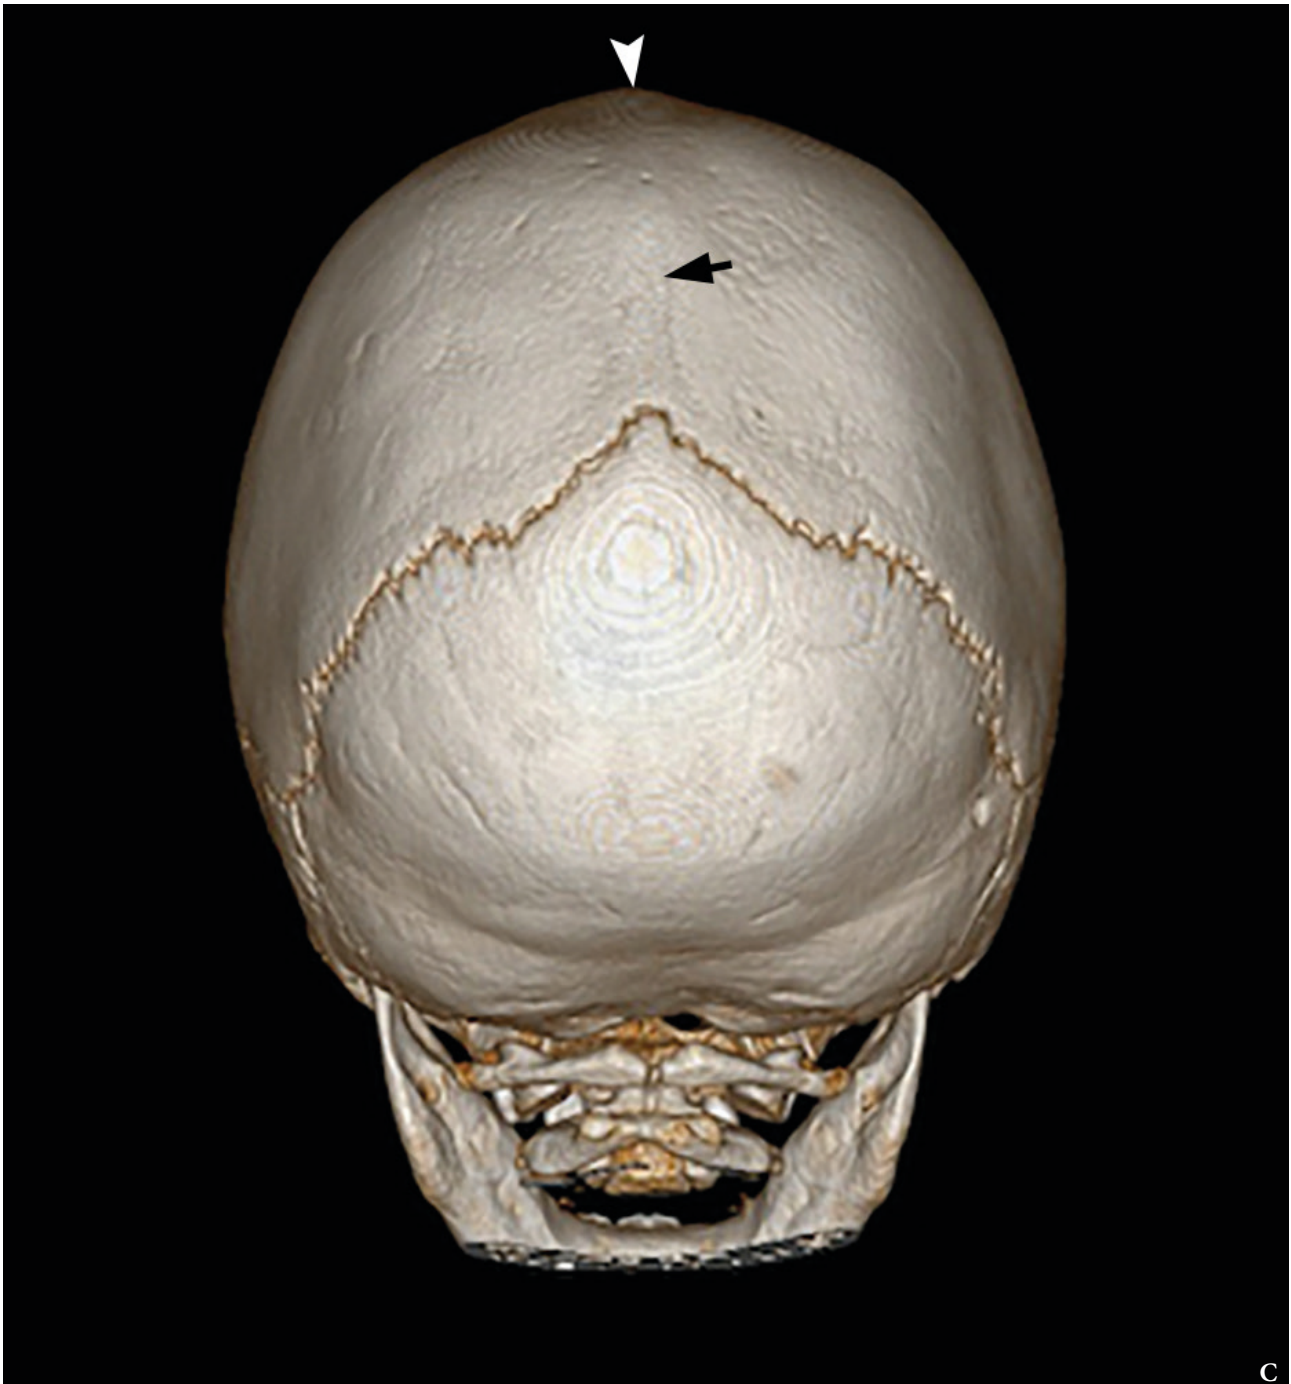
(cont'd). Posterior view (C) of 3D-CT volume-rendered image of a 6-month-old boy with premature, complete fusion (*arrow*) of the sagittal suture. It results in increased anteroposterior diameter, along with bitemporal narrowing due to restriction of biparietal growth. Prominent ridging (*arrowhead*) of the sagittal suture is observed, as well as frontal and occipital bulging. (Fig 1 continued on next page.)
